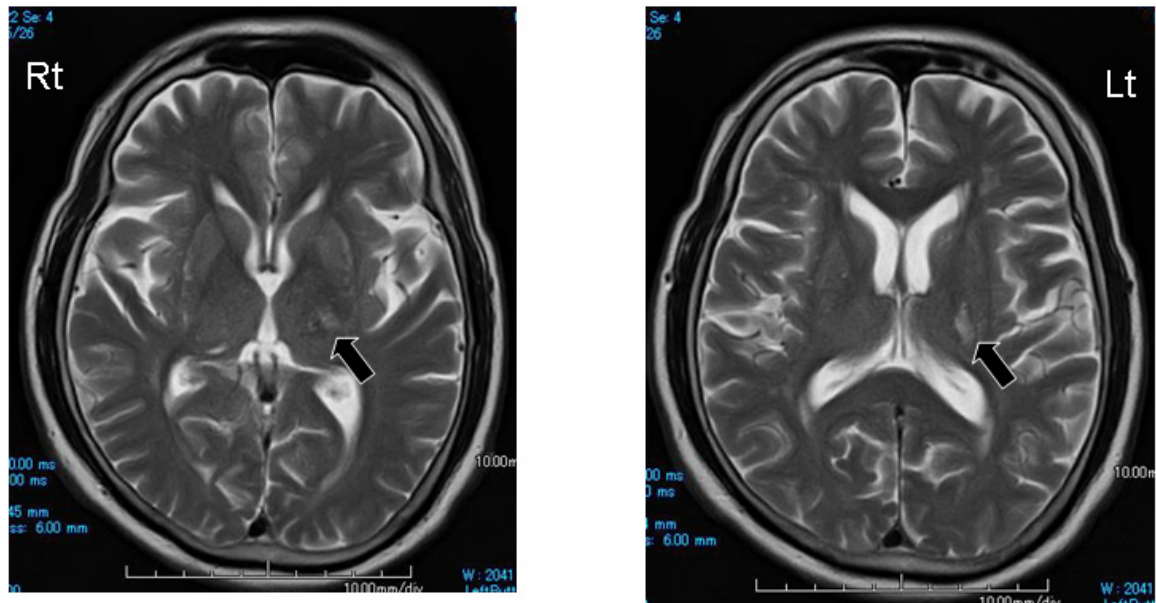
MRI T2-weighted image (8 weeks after onset)
